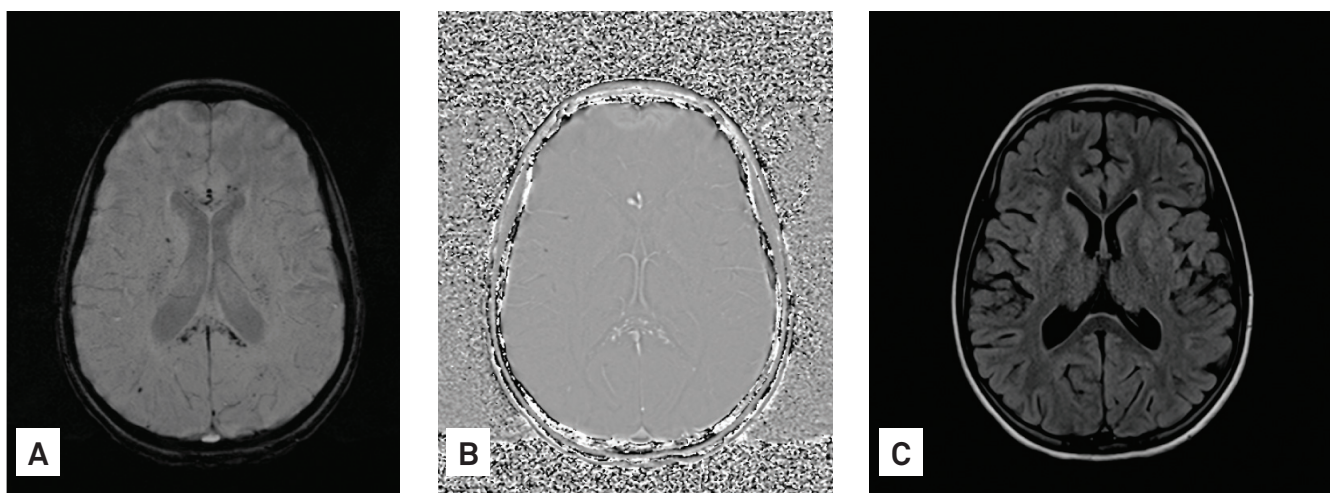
Susceptibility-weighted imaging (A) and phase images of susceptibility-weighted imaging (B) show multiple foci of low signal intensity on genu and splenium of the corpus callosum and subcortical white matter on susceptibility-weighted imaging, with high signal intensity on the phase images of susceptibility-weighted imaging, suggesting blood deposits. FLAIR image (C) on the same position shows no abnormalities.
